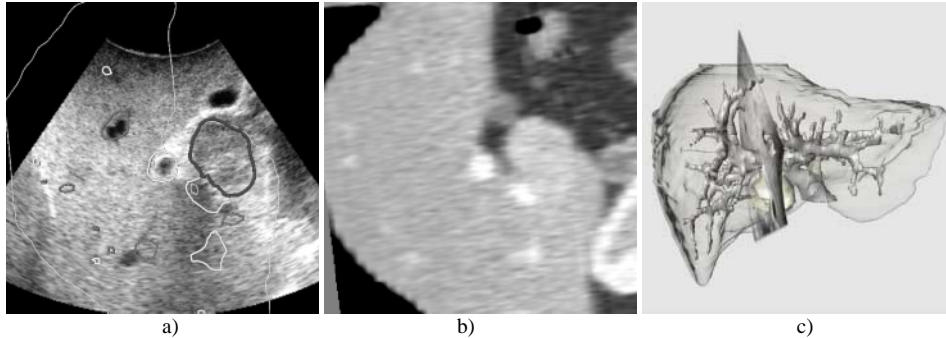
Intraoperative visualization possibilities. (a) US slice with different coloured intersection lines of preoperatively modelled tumour (dark and thick), portal veins (bright), hepatic veins (dark) and liver surface (bright and thin). (b) Corresponding CT slice. (c) Overview image showing portal veins, tumor, liver surface and location of US slice.
